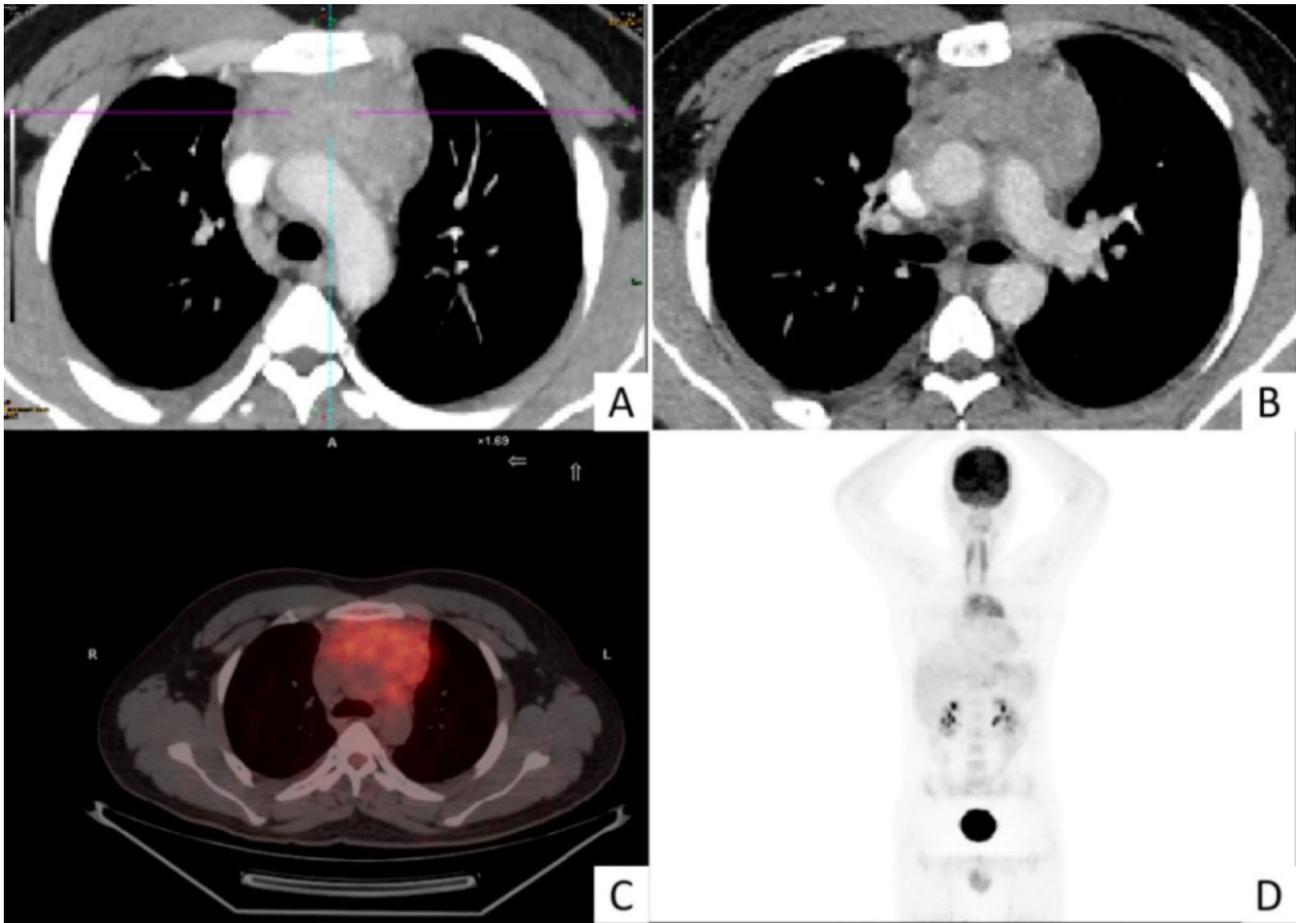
(A, B) Contrast-enhanced computed tomography showed a large mass visible in the anterior mediastinum, accompanied by uneven enhancement. (C, D) Positron emission tomography scan. 18 F- fluorodeoxyglucose (FDC) uptake on mediastinal mass
